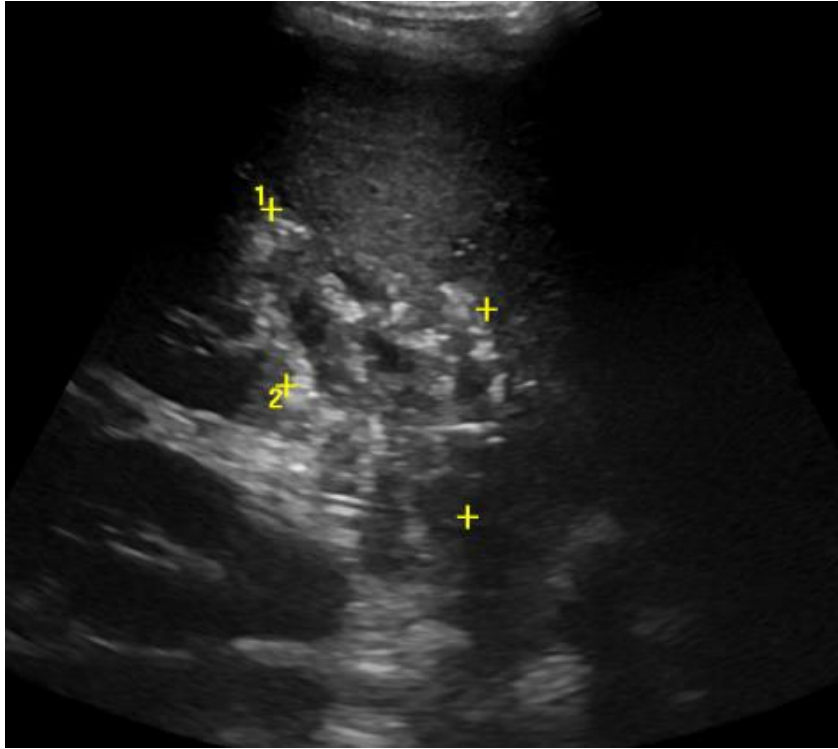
Blind shrapnel thoracoabdominal wound. Ultrasound reveals local disruption of the architecture of the right lobe of the liver.
